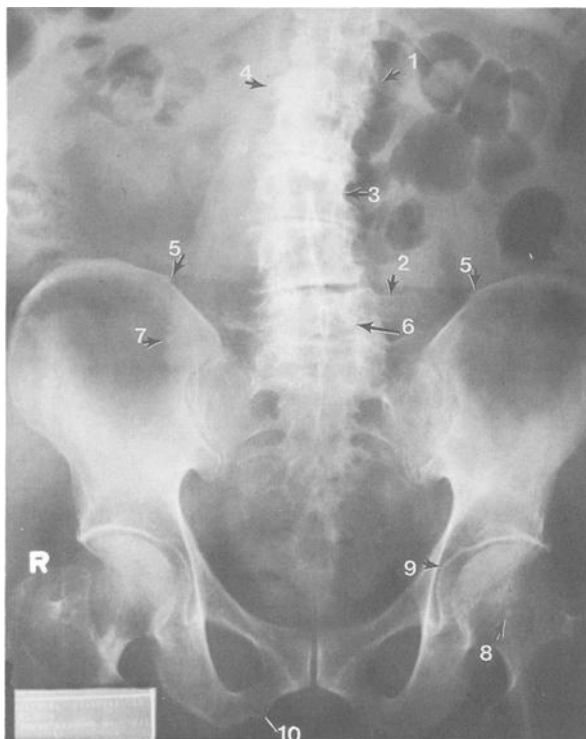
Premortem radiograph of the abdomen and pelvic region of the 76-year-old white male (taken one year before death). The numbers indicate the skeletal features (see text) used for comparison with a postmortem radiograph (see Fig. 2).
